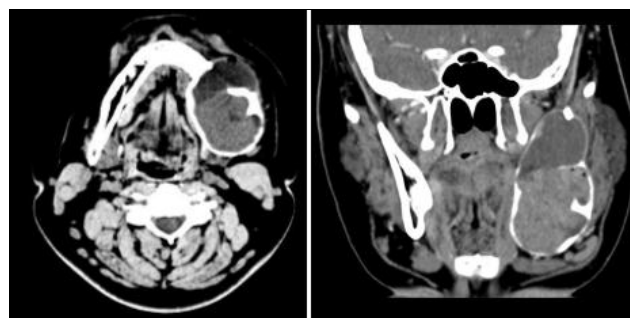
Axial and Coronal View CT Showing Extent of the Lesion
